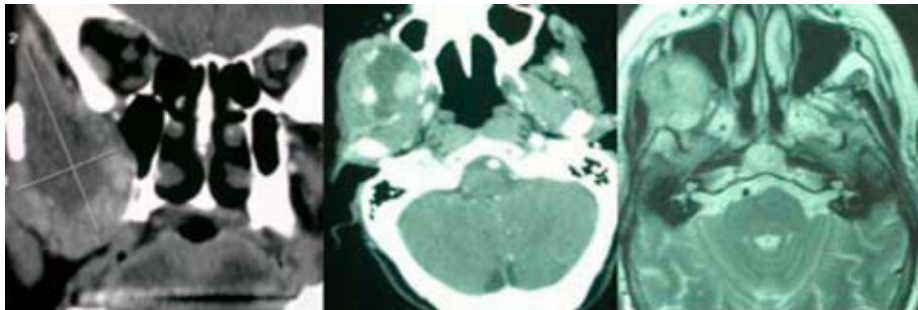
CT and MRI scans showing the tumour location in the infratemporal fossa.
